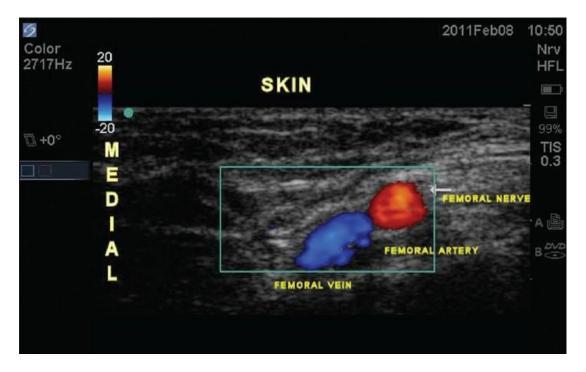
Identification of the femoral artery by Doppler flow. (4)
